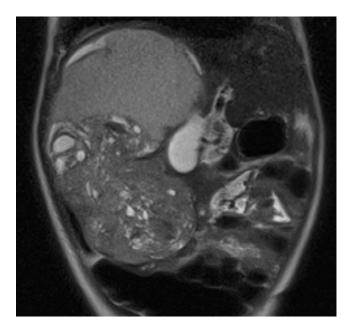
Coronal T2-weighted magnetic resonance sequence through the right hepatic lobe. Compared to the normal left lobe, the lesion is relatively T2 hyperintense. A large cystic component superior demonstrates intermediate T2 signal, compatible with the presence of hemorrhage into the cyst. The interior portion of the lesion demonstrates heterogeneous T2 signal with both cystic and solid components
